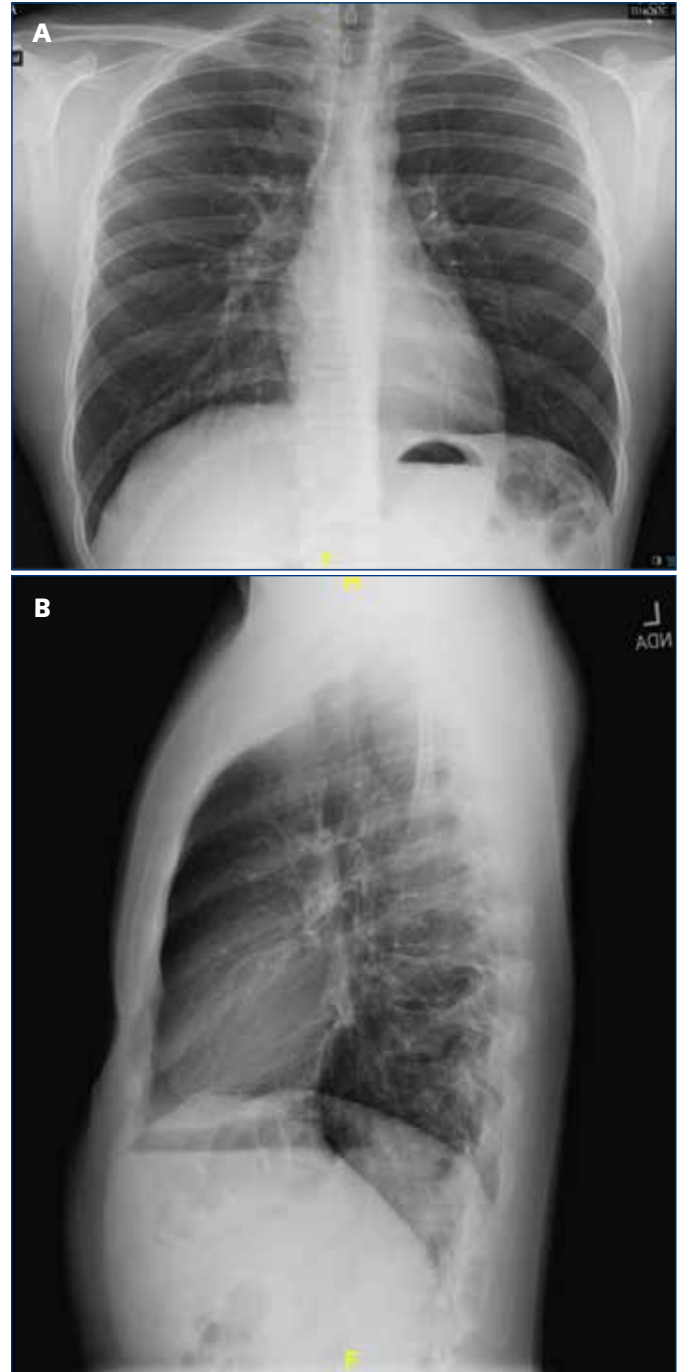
1B. Chest X-rays showing subcutaneous emphysema, pneumomediastinum
